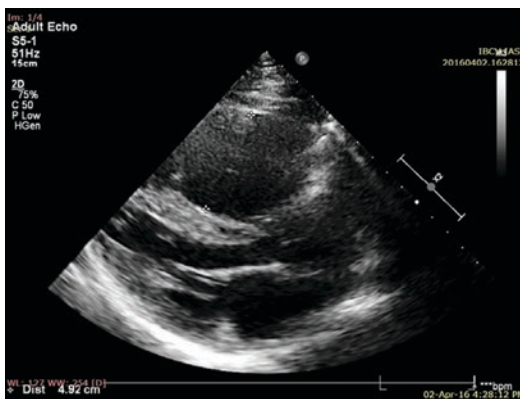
Ecocardiography, parasternal long-axis view, in a patient with severe pulmonary hypertension. Note the important dilation of the right ventricle and the interventricular septum bulging into the LV cavity, impairing its function.
